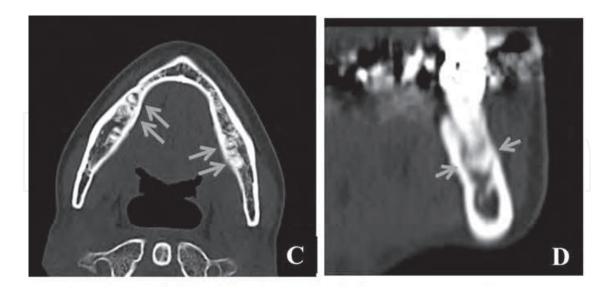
CT images (A, B) of a benign cementoblastoma in the mandible (arrows). CT images (C, D) of periapical cemental dysplasia in the mandible (arrows).
